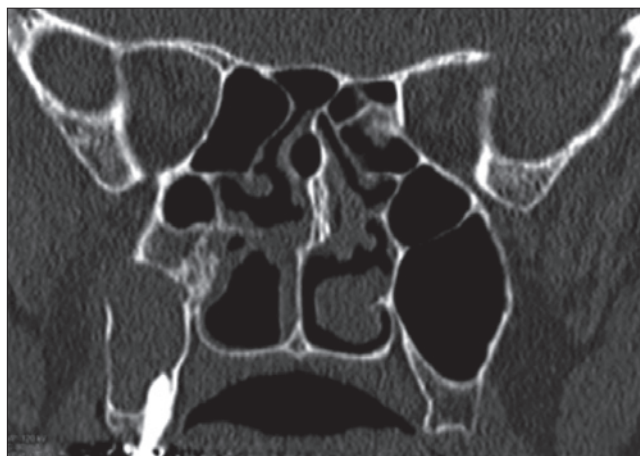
Maxillary cyst CT scan coronal view.
